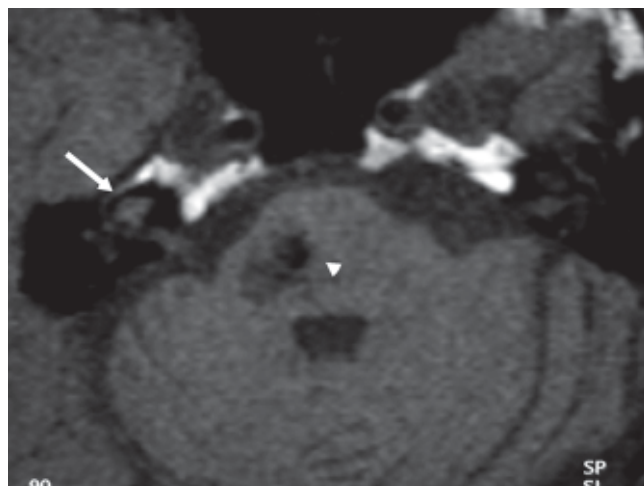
Unenhanced T1-weighted axial image showing high signal from the right cochlea (white arrow). There is also a hypointense area in the right hemipons (white arrowhead).
